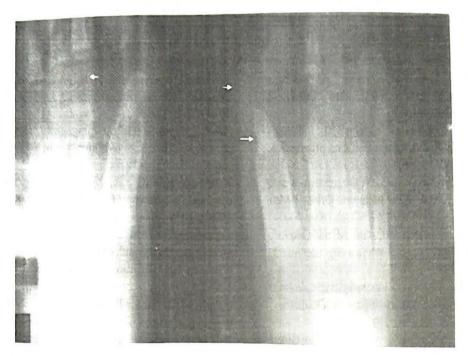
Radiograph of the feet showing bilateral short halluxes, halloux valga and synostoes of the first metatarsals and proximal phalanges. There is also bilateral syndactyly of the bases of 2nd to 4th toes.
